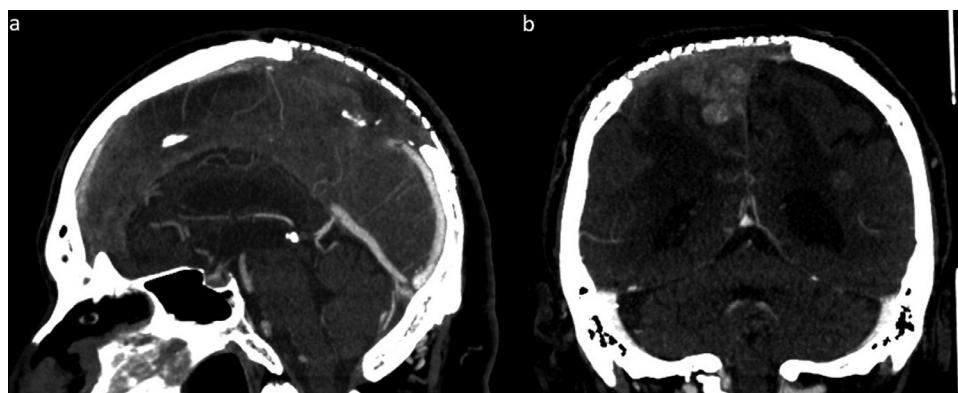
(a and b). A CT venogram with 3-dimensional (3D) reconstruction demonstrated inward displacement of the superior sagittal sinus. The extra-axial mass was destroying the posterior parietal bones on both sides of the vertex and extending into the right parietal area. In addition, there was a 3-centimeter area of completely destroyed bone as well as a 5-centimeter area of infiltration in the right parietal bone. A right frontal and parietal thin extra-axial subdural collection was noted. There was an approximately 13-millimeter length of the occluded superior sagittal sinus at the mass
